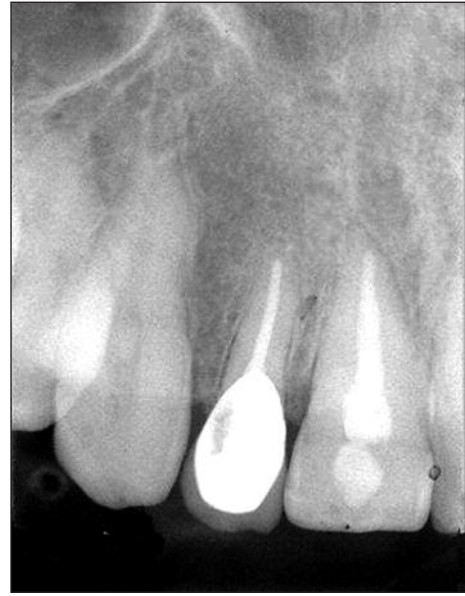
The radiographic image of the tooth after three years.
